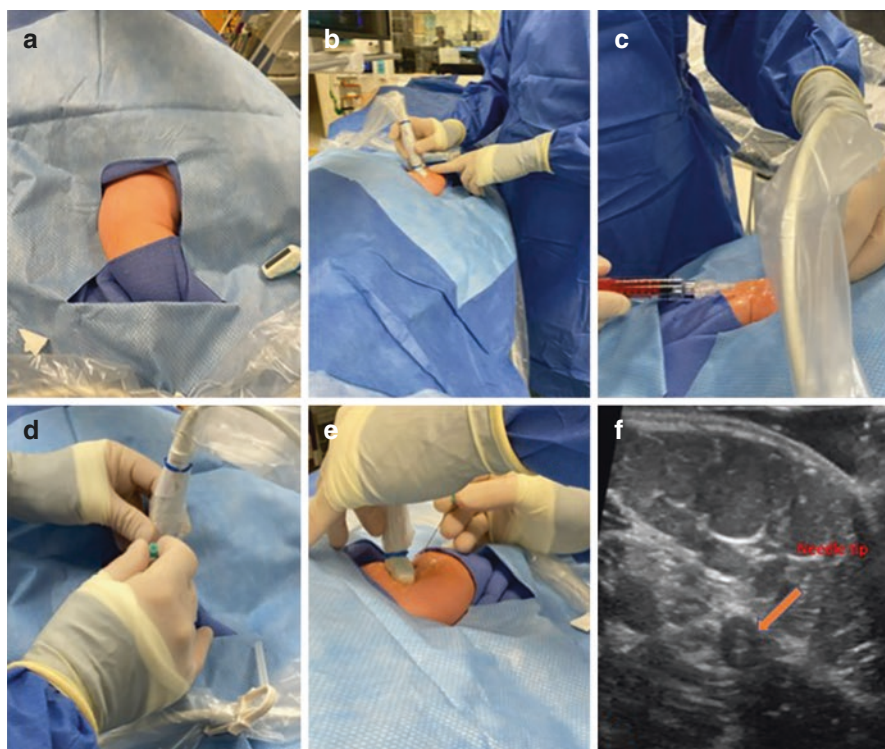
Steps of an image guided vascular access using an aseptic Seldinger technique (part 1). (a) Prepped and draped sterile field (b) Evaluation of the target vein and choosing entry site with ultrasound (c) Administration of local anesthesia (d) Venous access (Long-axis technique) (e) Venous access (Short-axis technique) (f) US image demonstrating the needle tip in the target vein
